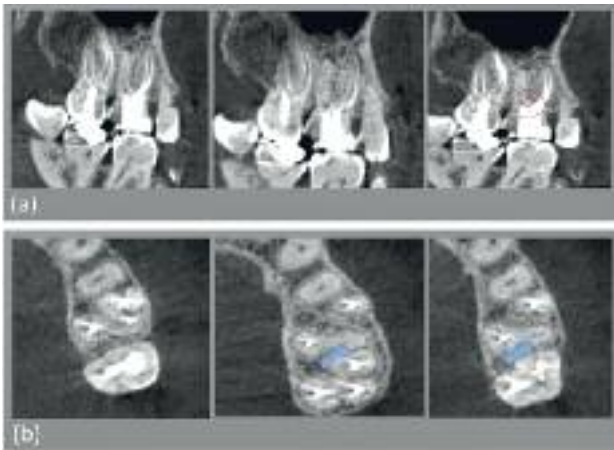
Small volume CBCT scan (ProMax 3Ds; Planmeca OY, Helsinki, Finland). (a) Coronal views showed an untreated disto-buccal root canal, a periapical lesion associated with the distal root, and a furcal perforation (red circle). (b) Sagittal CBCT sections confirmed the untreated disto-buccal root canal (blue arrows).
